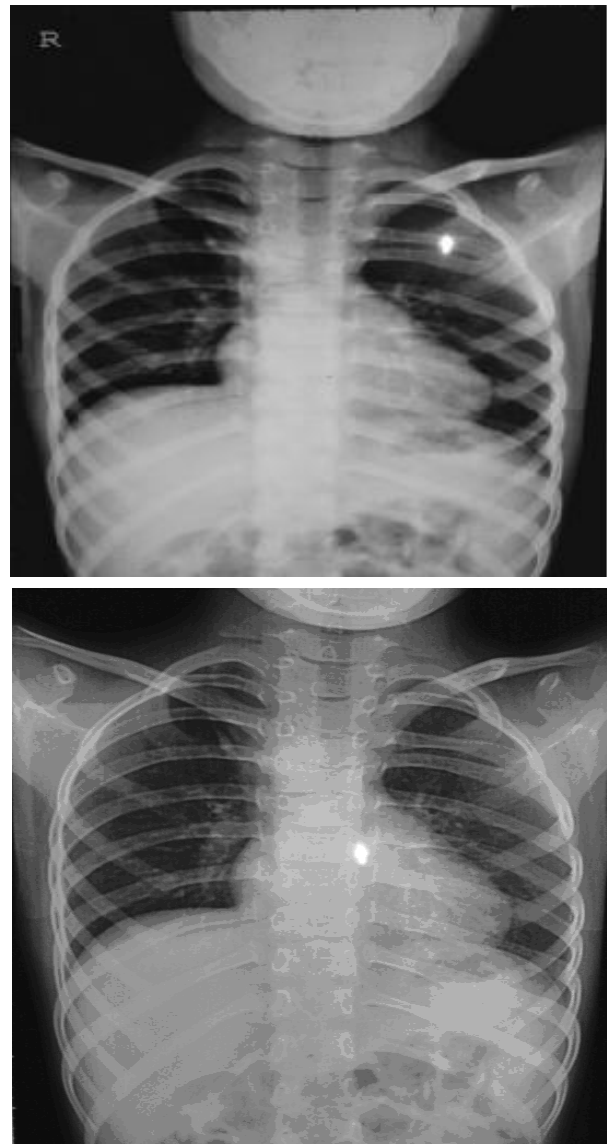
1 (a, b): X-ray chest P/A View: Borderline cardiomegaly, acute cardiophrenic angle, concave pulmonary bay and mild oligoemia.
